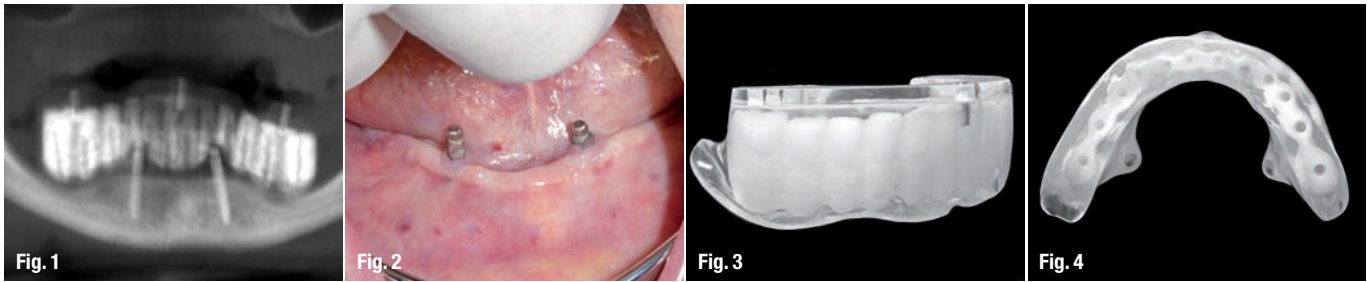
_Initial radiograph.
